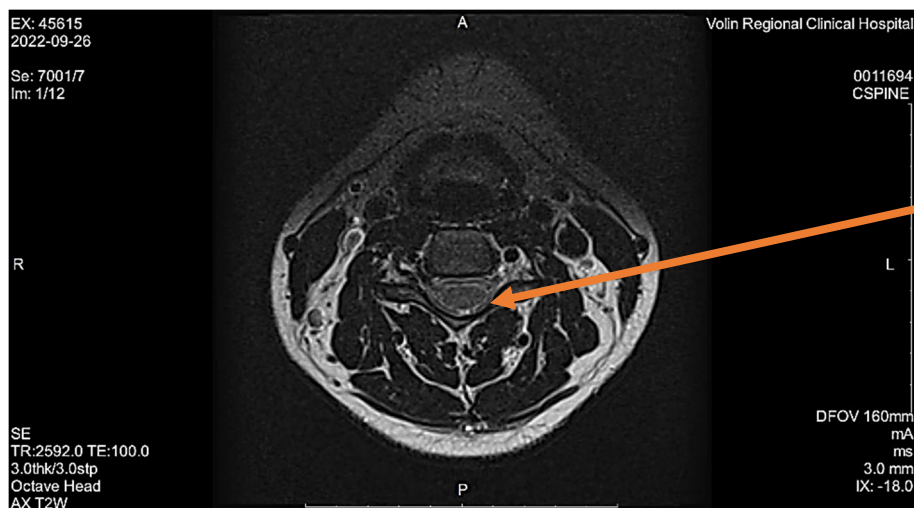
Magnetic resonance imaging of the cervical spine on September 26, 2022, axial plane, T2 sequence. Hyperintensity in the posterior cords of the spinal cord (arrow)
